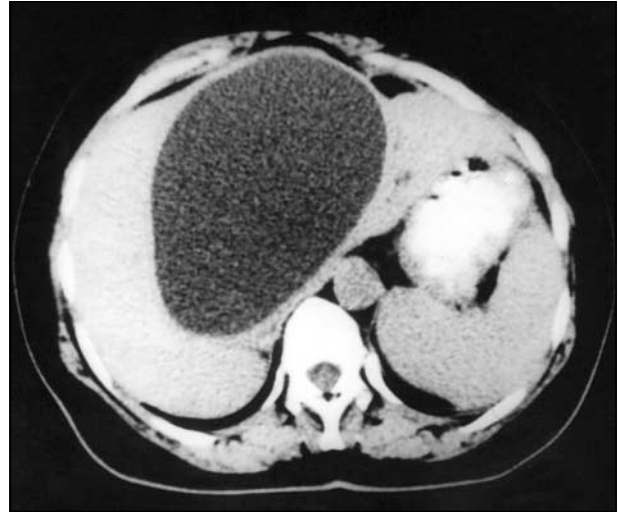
Preoperative computed tomographic image.
